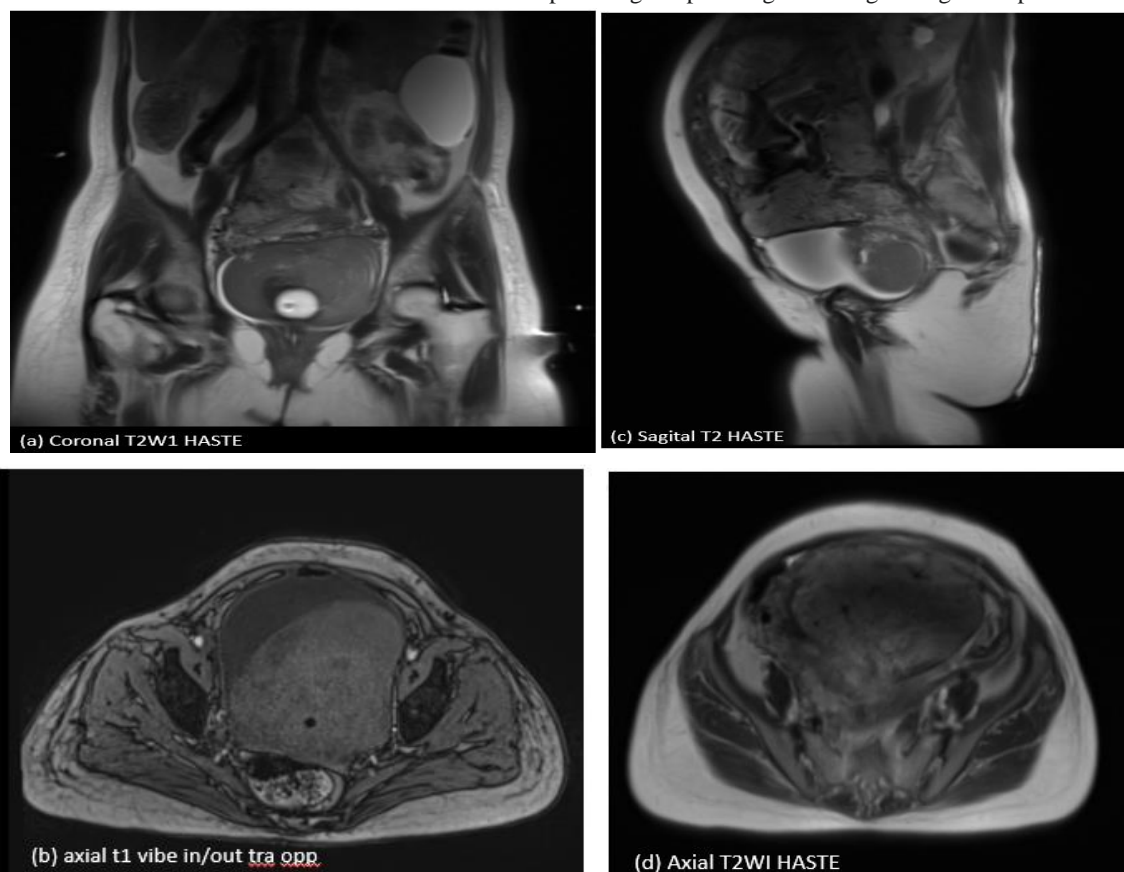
(a) coronal T2WI HASTE MRI image show direct placental infiltration of the posterolateral wall of the urinary bladder, accompanied by intravesical blood clot formation.
